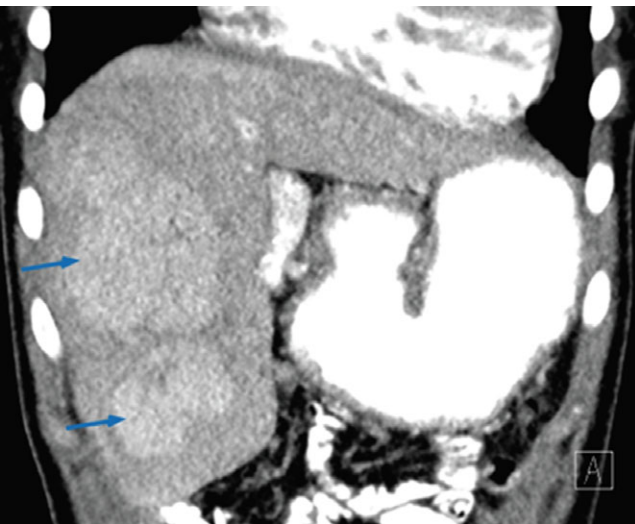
CT abdomen demonstrating hepatomegaly with two lobulated liver masses (blue arrows) that appear to be multifocal nodular hyperplasia.
